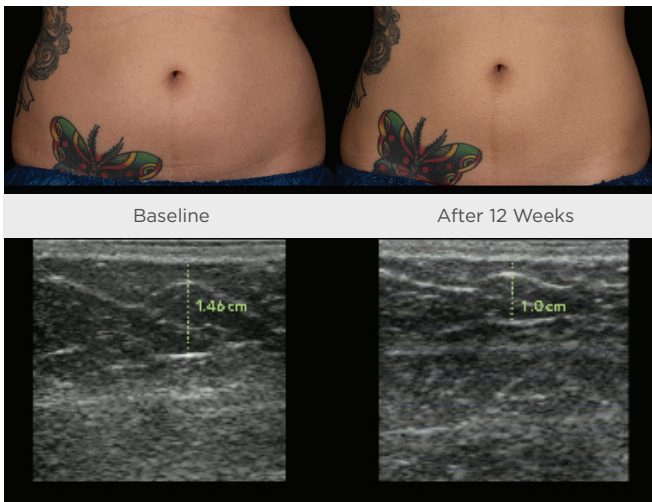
Photos courtesy of Stephen Ronan, M.D. Shows patient 1 who received a 10-minute treatment on the right flank, a 20-minute treatment on the left flank, and 20-minute treatment on the abdomen. Ultrasound shows 4.6mm or 32% fat reduction.
